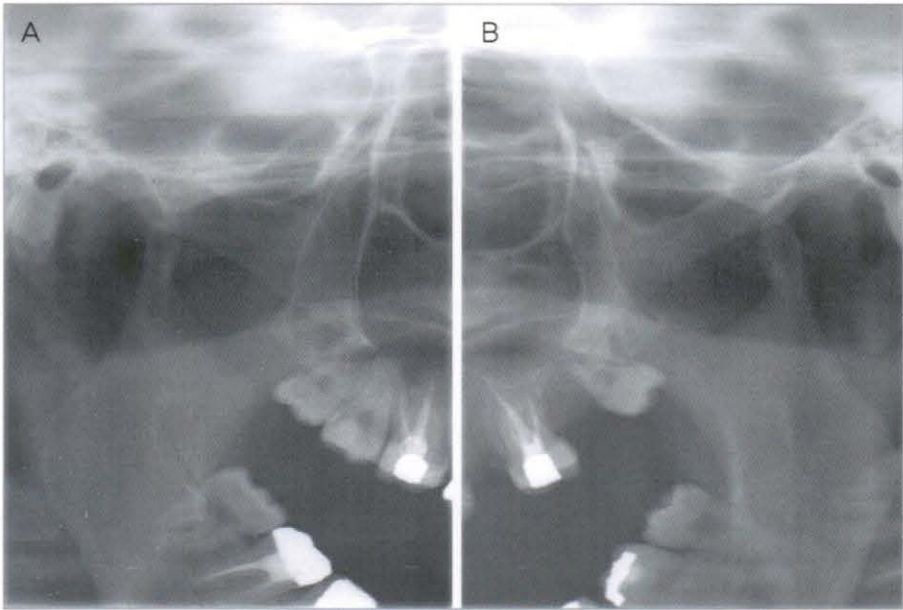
Pre-treatment TMJ panoramic radiograph (2005, 228)
